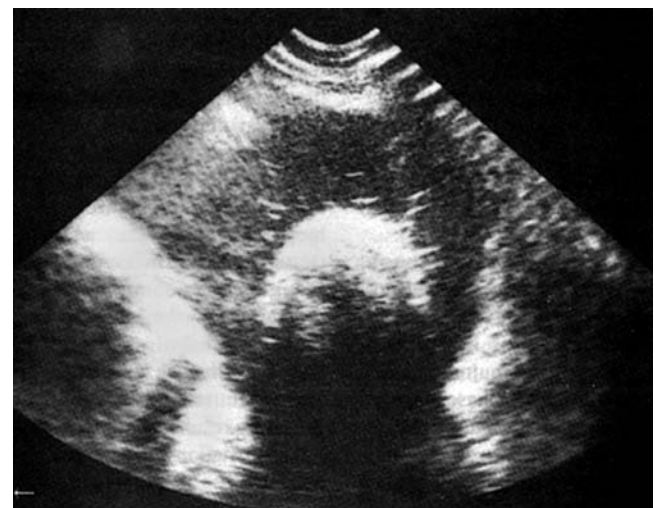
Ultrasound showing a pelvic mass.
